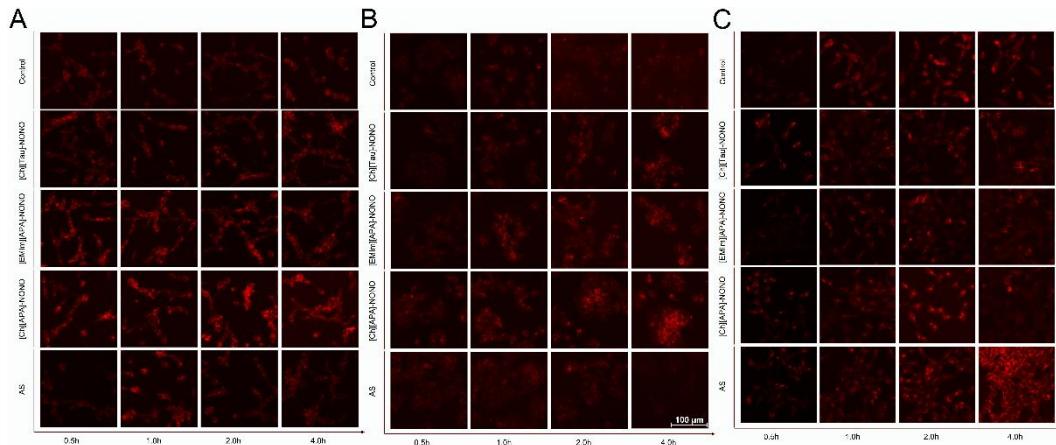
Temporal changes in RNS production in cells treated with IL-NONOates or Angelic's salt. Angelic's salt (AS). (A) CT-26 (B) MCF-7 and (C) HEK-293 cells.
